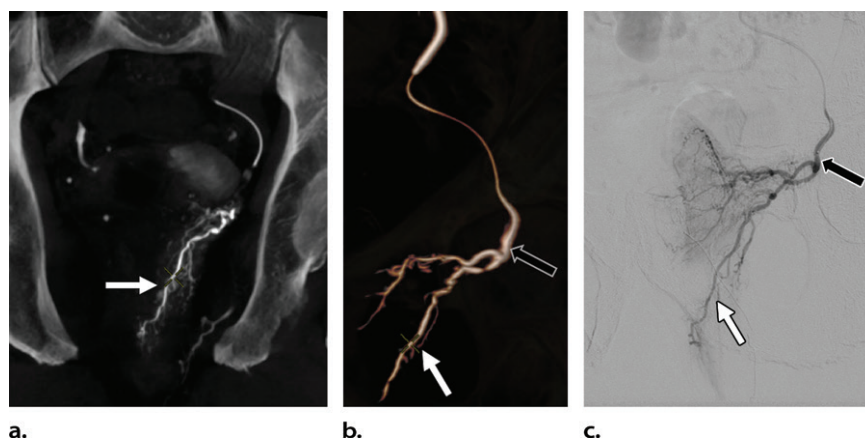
Maximum intensity projection (a), volume-rendered CBCT reconstruction (b), and DSA (c) images in a 66-year-old man show a rectal branch (white arrow) originating from the prostatic posterolateral peripheral zone branch (black arrow in b and c).
